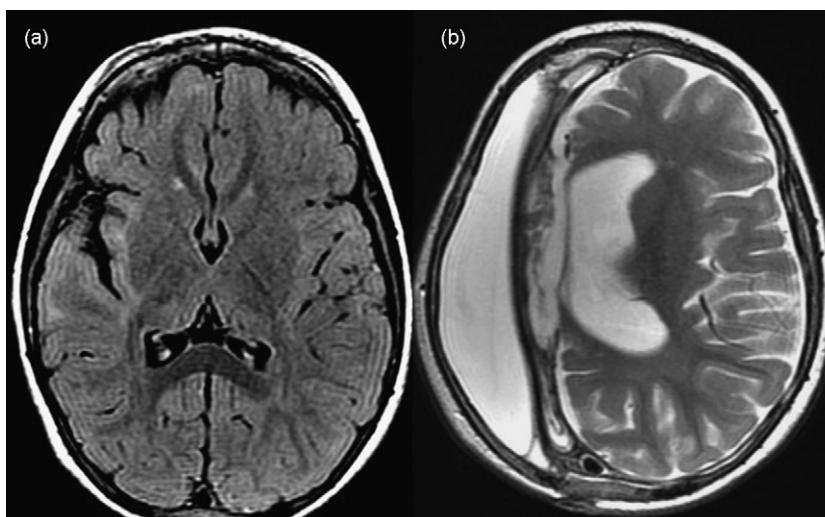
Rasmussen encephalitis. (a) Preoperative axial FLAIR MR images showing multiple areas of increased signal in the sub-cortical white matter of right insula, temporal and frontal lobes due to parenchymal gliosis, associated to a mild hemi-atrophy of the right hemisphere (see the enlarged right Sylvian fissure). (b) Postoperative axial post-surgical T2w MR image (2 years after anatomical hemispherectomy).
